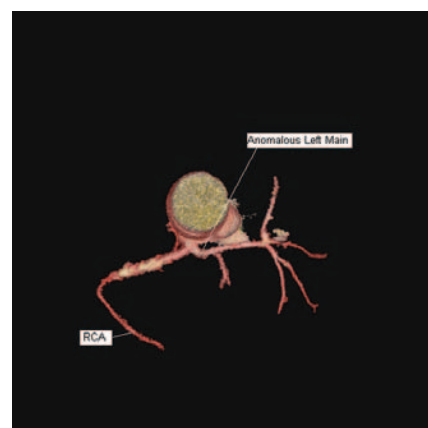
Cardiac computed tomography (volume rendering) showing the anomalous left main artery and its branches. RCA, right coronary artery. www.medreviews.com
